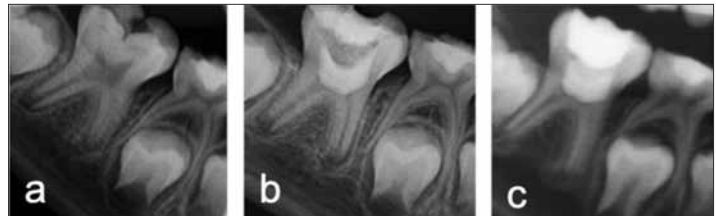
Radiographic appearance of case 2; a – preoperative; b – postoperative; c – postoperative 12-month follow-up
